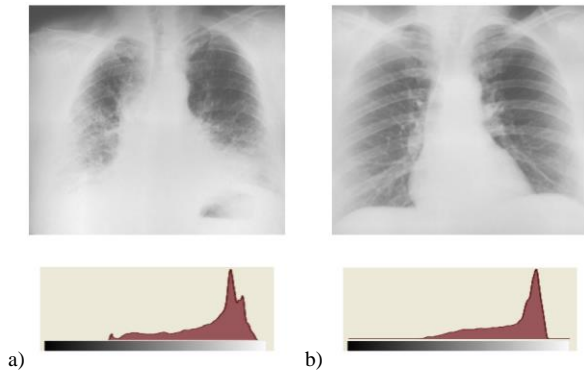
Examples of underexposed X-rays and their histograms.
